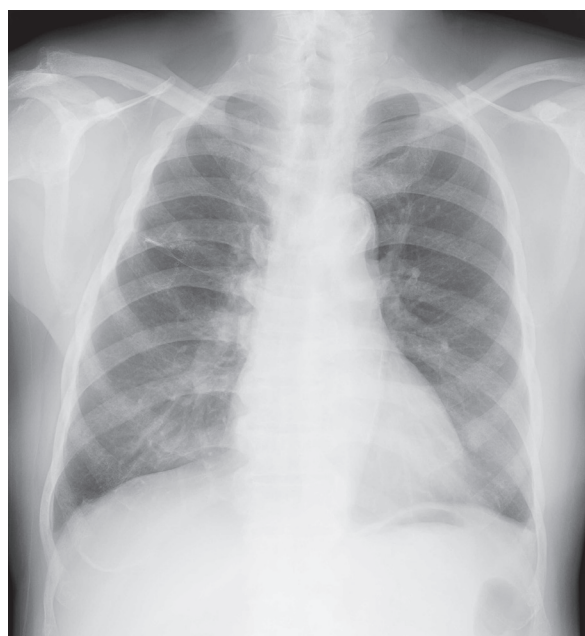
Chest X-ray showed the pleural effusion in regression after treatment.
